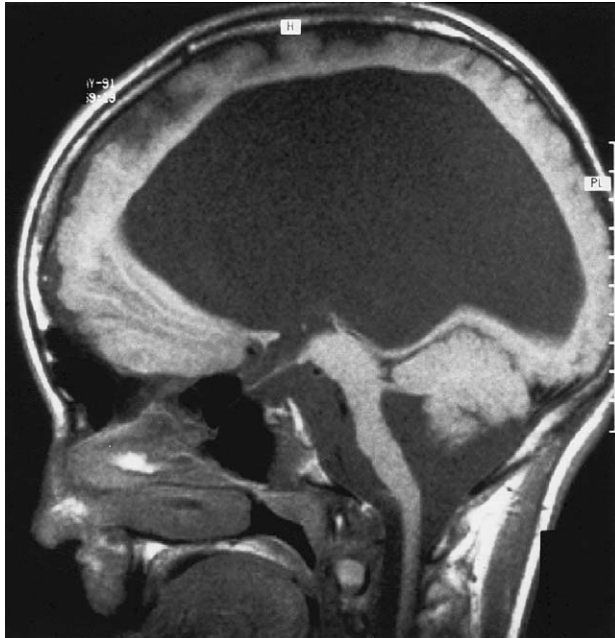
MRI features of the brain of an MEB patient. Sagittal view showing an enlarged lateral ventricle, thin corpus callosum, absent pons, abnormal tectum, and cerebellar atrophy with absent vermis. The patient also has a pachygyria-type cortical migration defect.
